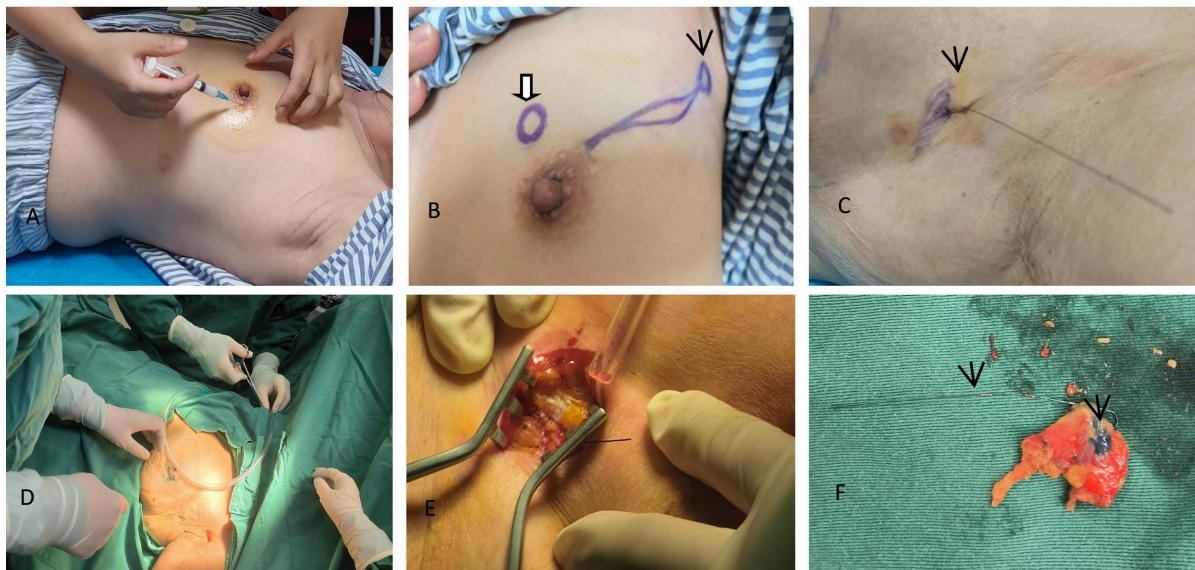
Sentinel lymph node ultrasonography and intraoperative resection to remove the sentinel lymph node. (A) Percutaneous injection of ultrasound contrast agent; (B) Sentinel lymph nodes were found along the lymphatic ducts were visualized and projected on the body surface at the location of the marked lymphatic ducts and lymph nodes (large arrows are breast lumps, small arrows are sentinel lymph nodes); (C) Ultrasound-guided placement of positioning hook silk in the sentinel lymph node; (D) Patient was injected with intraoperative melphalan to locate the sentinel lymph node; (E) Intraoperative finding of the sentinel lymph node marked with positioning hook silk; (F) Removal of the marked sentinel lymph node, with the positioning hook silk and blue color in the lymph node visible.
